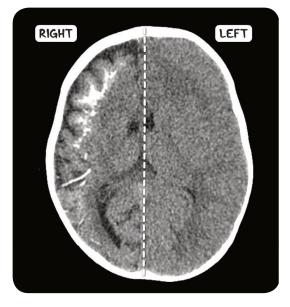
A CT scan of the head in the axial plane of an individual with Sturge-Weber syndrome. There is calcification and volume loss of the cerebral cortex on the right side.
